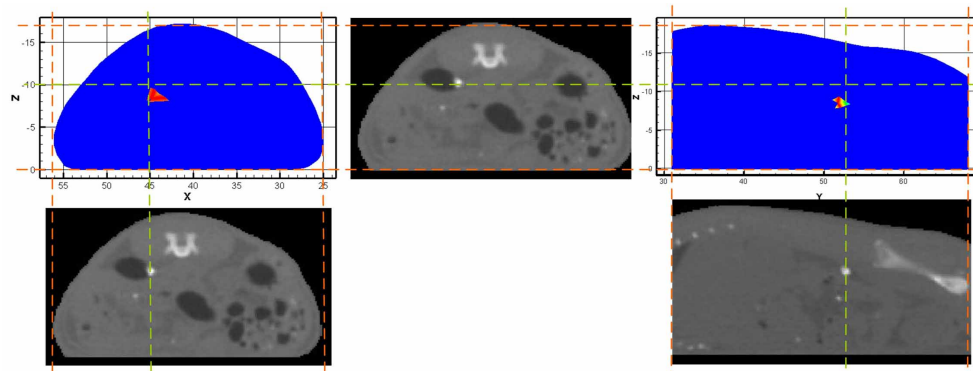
The experimental BLT reconstructions with the proposed method. The results are shown in lateral and vertical cross sectional views, compared with the source location in the corresponding CT slices. It is noted that all the reconstructed values above zero in the slices are displayed for the results.
